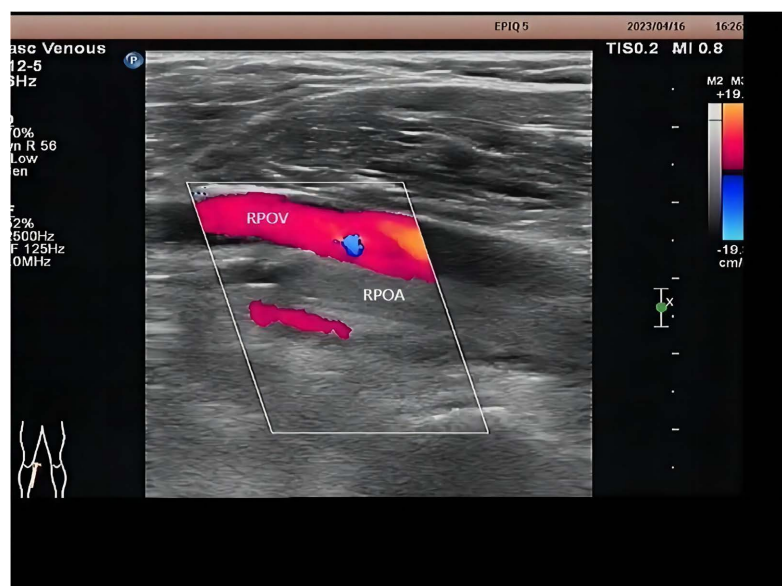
Ultrasound: hypoechoic filling was observed in the right popliteal artery without obvious blood flow signal.
